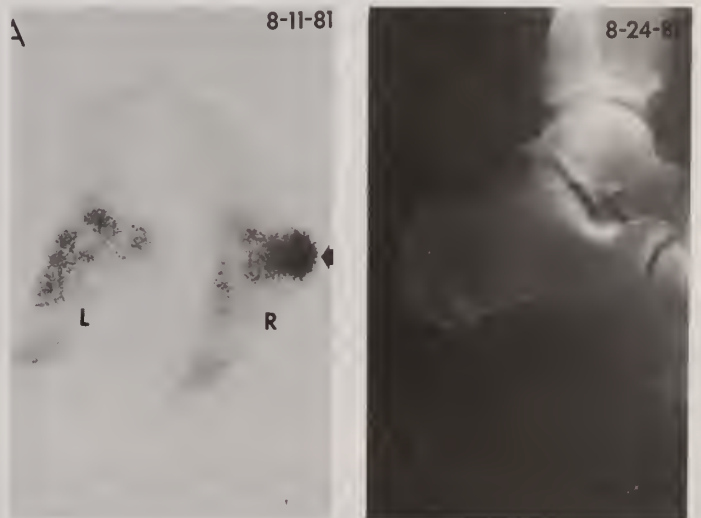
Bone scan (A) demonstrates an intense focal area of increased uptake (arrow) in the right calcaneus. Radiograph (B) showing sclerotic changes (arrow). This is the most common abnormality seen in our service.
